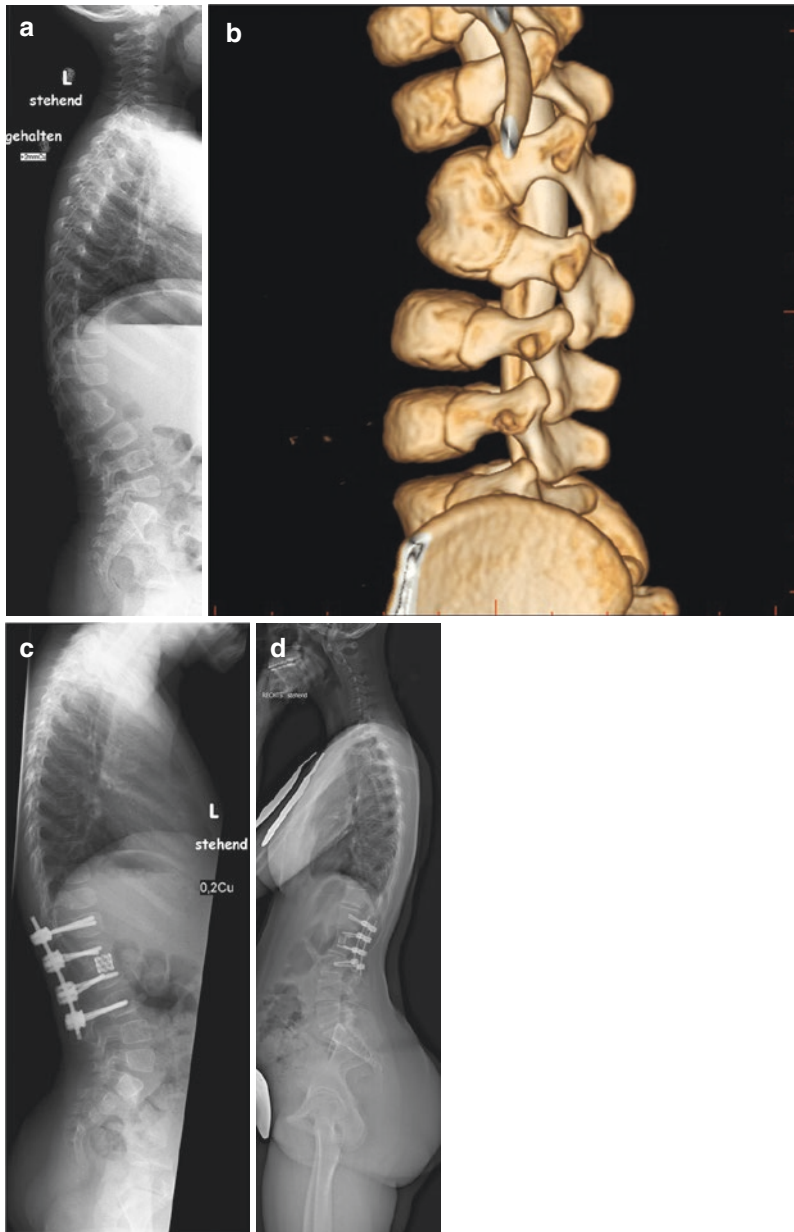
A 2-year-old girl with the anterior bar at L2–3 (failure of segmentation); lateral radiograph (a) and 3D-CT (b). Postoperative lateral radiographs following osteotomy of the bar through a posterior approach, insertion of a cage and instrumentation L1–4 (c); follow-up at the age of 14 years (d). Please note the correction to a physiological sagittal profile and the further growth of the spine. Lordosis increases by anterior growth against the posterior instrumentation (tension band)
